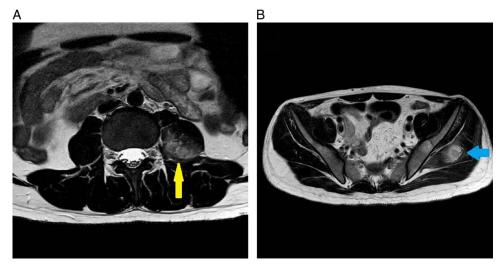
MRI showing hyper and hypointense signal indicating inflammation and abscess formation in left psoas (A) and left gluteal medius muscle (B).
